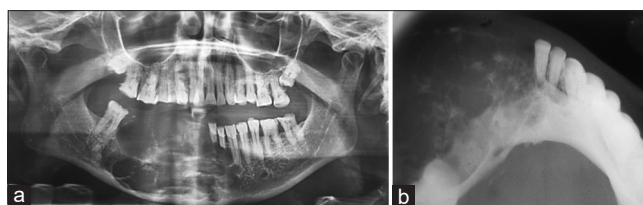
(a) Orthopantomograph showing multilocular radiolucency extending from 33 to 46 region, with intact lower border of mandible with root resorption of 31 and 32. (b) Occlusal radiograph showing buccal cortical expansion with internal multilocular radiolucency
